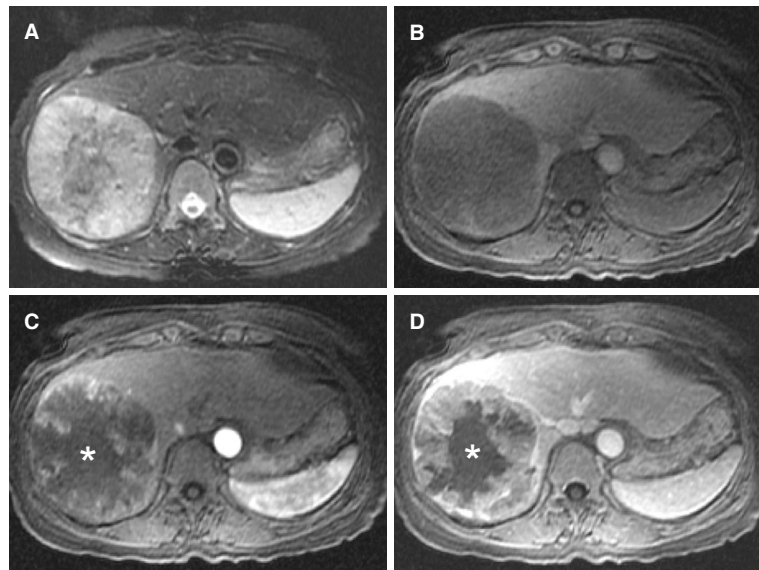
Contrast-enhanced magnetic resonance imaging showing a large liver mass. The axial T2-weighted fat-suppressed image (A) shows a large hyperintense mass replacing most of the right hepatic lobe. The corresponding T1-weighted fat-suppressed pre-contrast (B), arterial phase post-contrast (C) and delayed post-contrast (D) images demonstrate hypointensity with patchy arterial hyperenhancement and washout with capsule appearance of the periphery and central necrosis (asterisk)
